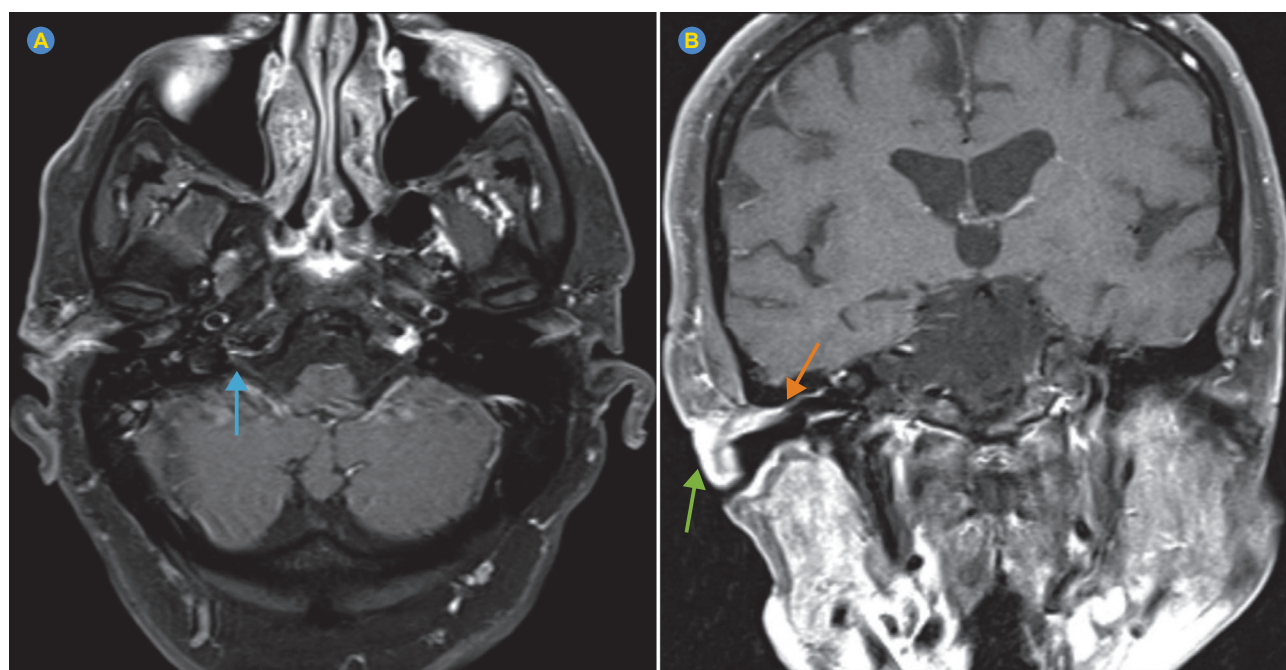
Magnetic resonance imaging T1 post-contrast sequence in axial section (A) and coronal section (B) demonstrating focal enhancement of the canalicular right facial-vestibulocochlear nerve complex (blue arrow) and an avid enhancement of the right external auditory canal (orange arrow) and external ear/ pinna (green arrow)
